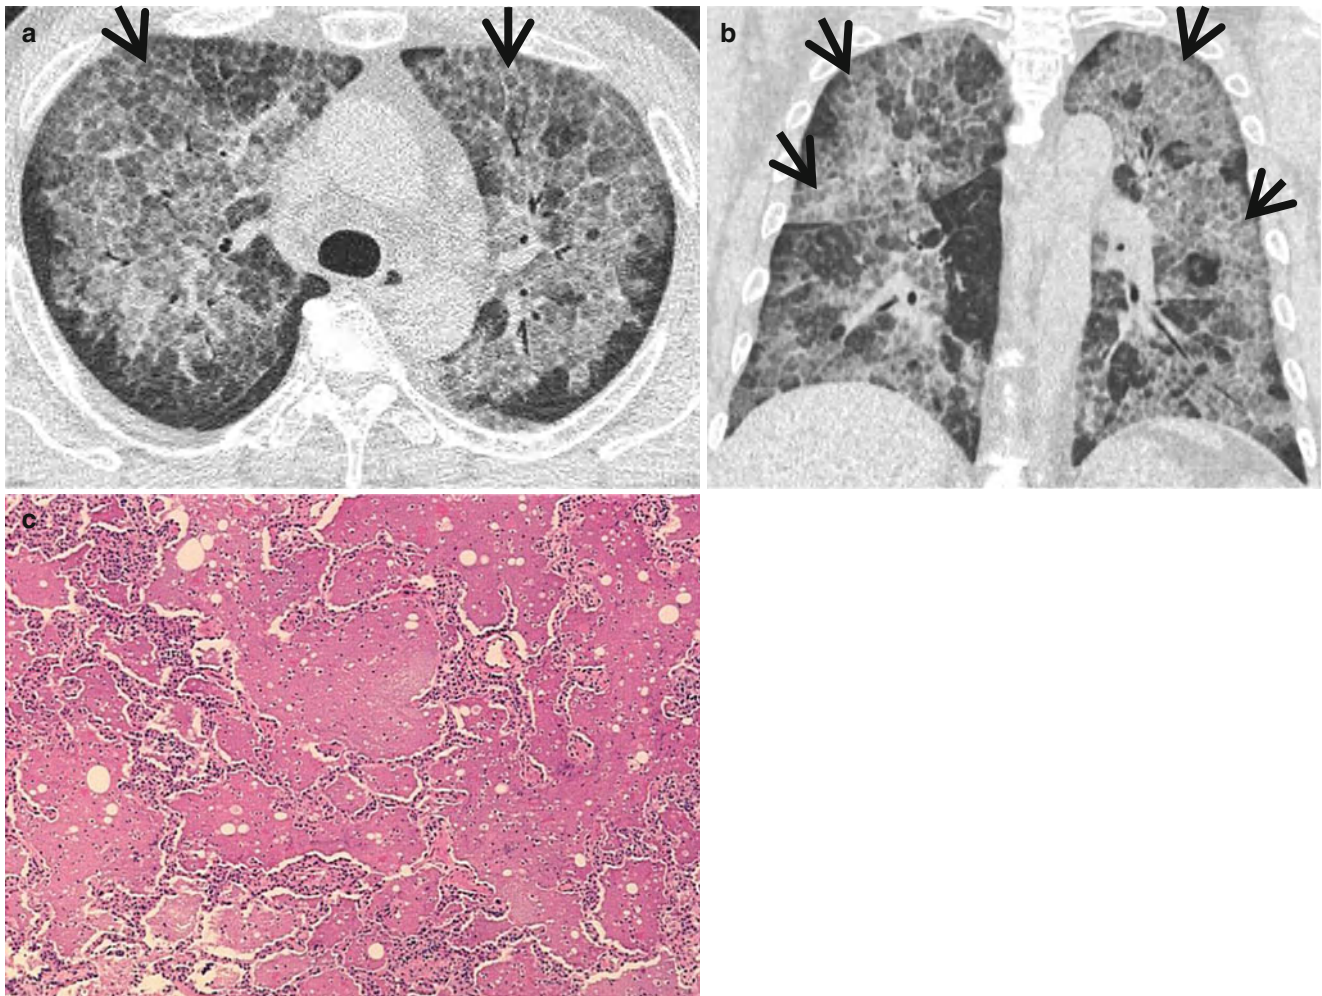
Pulmonary alveolar proteinosis in a 52-year-old man. (a) Lung window image of CT scan (1.5-mm section thickness) obtained at level of azygos arch shows diffuse ground-glass opacity containing internal reticulation (crazy-paving appearance, *arrows*) in both lungs. Subpleural sparing is seen. (b) Coronal reformatted image (2.0-mm
